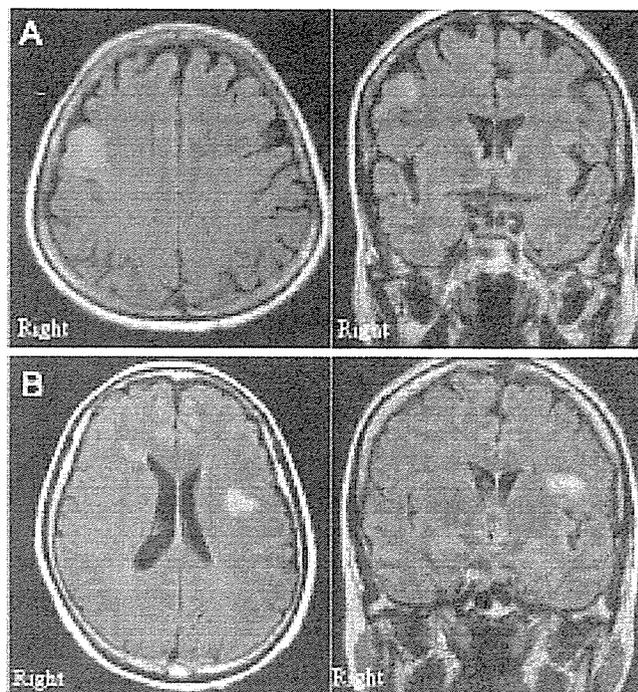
Fluid-attenuated inversion-recovery MR images showing a hyperintense lesion in the right MFG of the patient in Case 21 (A) and in the left IFG and MFG of the patient in Case 22 (B). Hyperintense lesions suggest glial-origin tumors because of unclear tumor margins.
